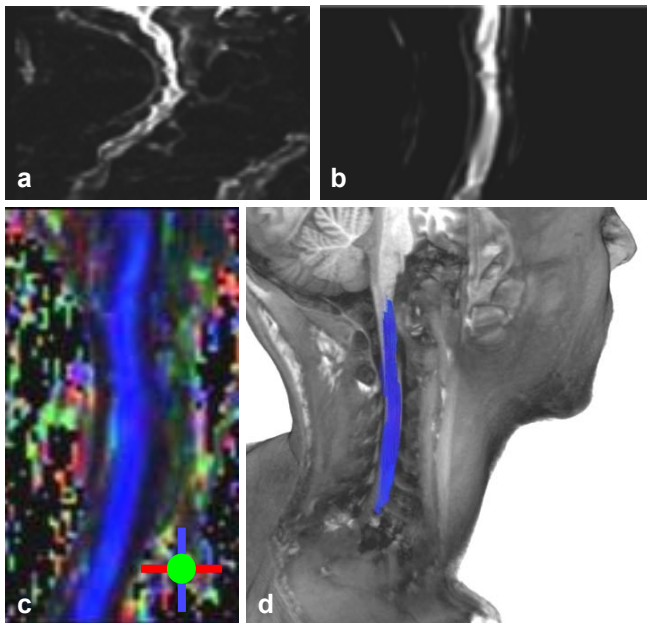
a: Sagittal view of a raw EPI T2-weighted human cervical spinal cord at  $b = 0 \text{ s/mm}^2$ . b: Same image corrected from susceptibility artifacts using non-linear registration method. c: FA color-map computed from all dMRI dataset. Color code corresponds to principal diffusion directions. d: 3-D reconstructed anatomical MRI with an overlay of fiber tracts.
